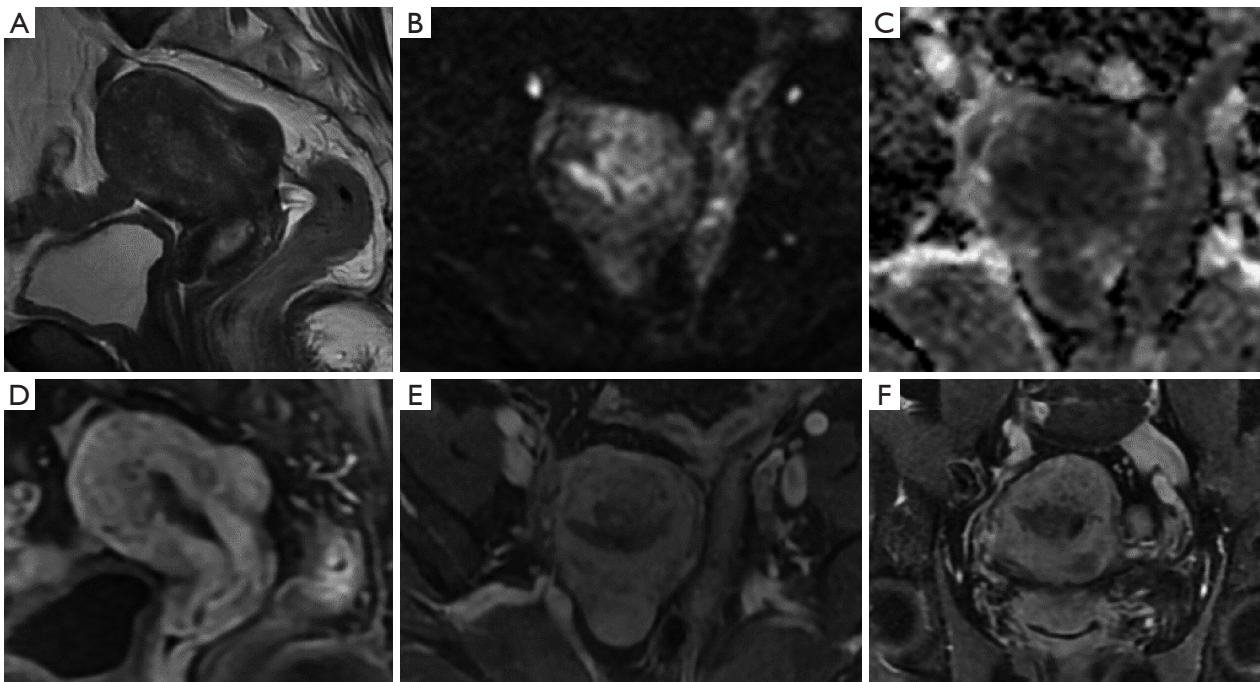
A 61-year-old patient with an endometrioid cancer (G1) coexisting adenomyosis and surgical pathology confirmed FIGO stage IA. (A) sagittal oblique T2WI, (B) axial diffusion weighted ($b=1,000 \text{ s/mm}^2$), (C) axial apparent coefficient diffusion map, (D) sagittal delayed-phase T1CE scan 150 s after gadolinium chelate injection, (E) axial oblique delayed-phase T1CE scan 180 s after gadolinium chelate injection, and (F) coronal delayed-phase T1CE scan 240 s after gadolinium chelate injection. The spatial relationship between the adenomyotic lesion and the cancer foci is adjacent. Diffuse adenomyosis is poorly demarcated from endometrial cancer, which is difficult to diagnose the depth of myometrial invasion on T2WI and DWI. T1CE increases the contrast between the lesions. Signal differences between endometrial cancer and adenomyosis at the continuation should be carefully discerned on T1CE. G, grade; FIGO, International Federation of Gynecology and Obstetrics; T2WI, T2-weighted imaging; DWI, diffusion-weighted imaging; T1CE, T1-weighted contrast-enhanced.
